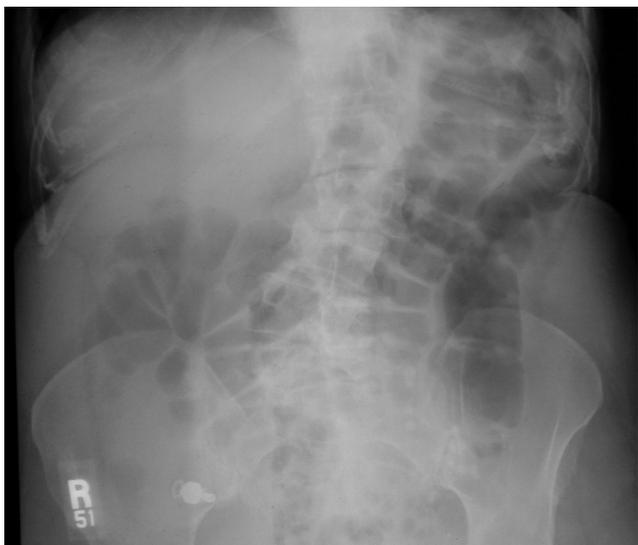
Plain radiograph confirming retention of video capsule.
